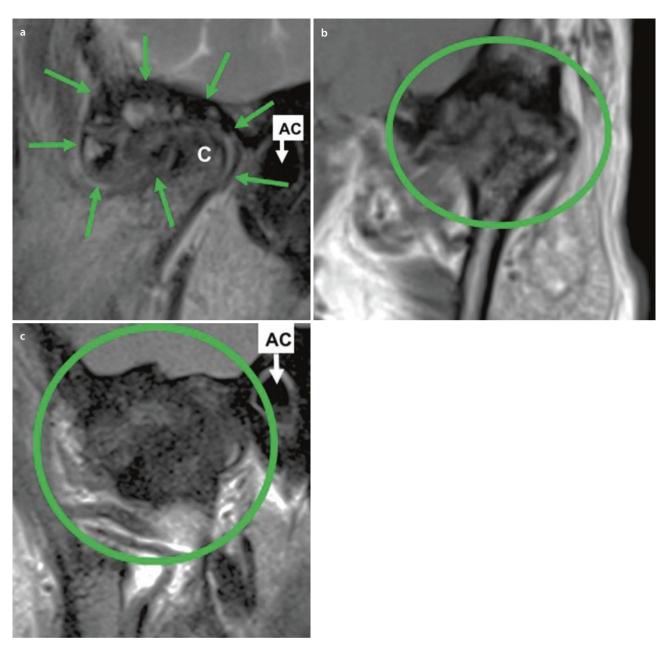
a MRI sagittal view of TMJ ankylosis. "C" identifies the condylar head. The bony mass outlined by the green arrows surrounds the condyle. AC auditory canal. b Coronal view shows bony continuity of the condyle and fossa. c Sagittal view of another case
